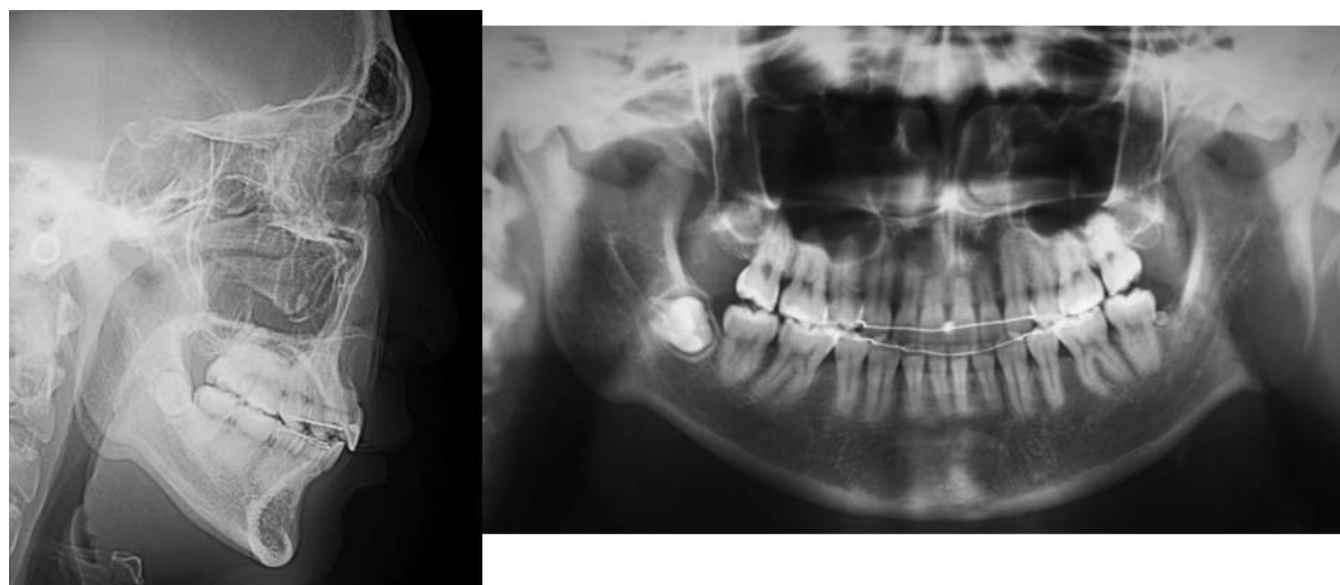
Cephalometric and panoramic radiographs 3 years after retention (age 20 years 8 months).
